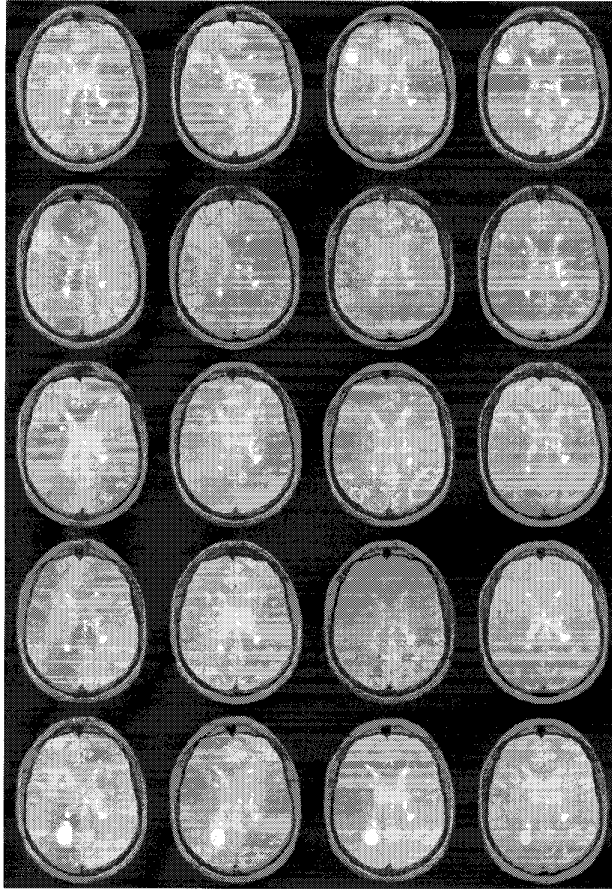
A series of MRI slices of a patient taken several weeks apart, over a period of eight months. Shown are the results of reslicing and normalizing each subsequent MRI scan, relative to the first scan, so that, in principle, the same slice of the anatomy is shown. One can easily see the changes in lesions in the upper left and lower left, over time.
